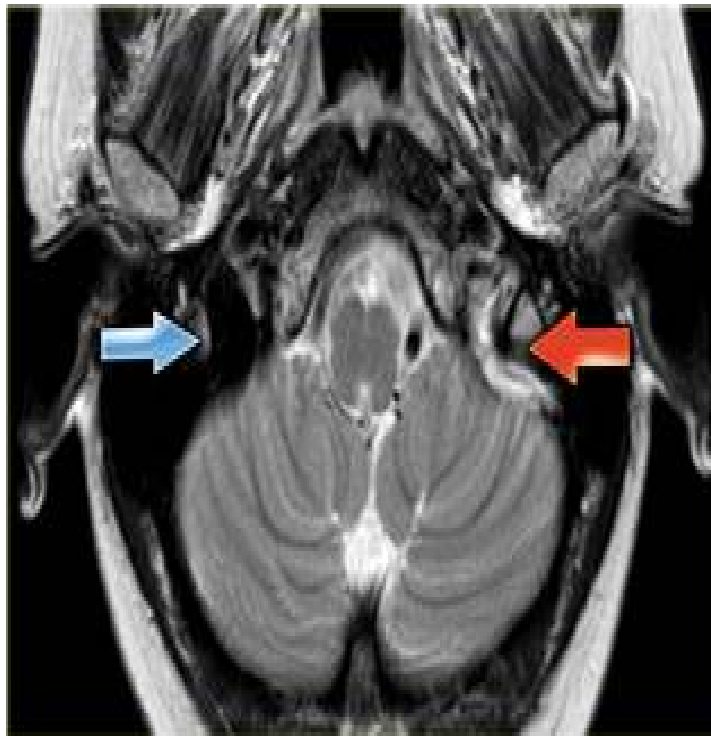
MRI - SIGMOID SINUS THROMBOSIS
